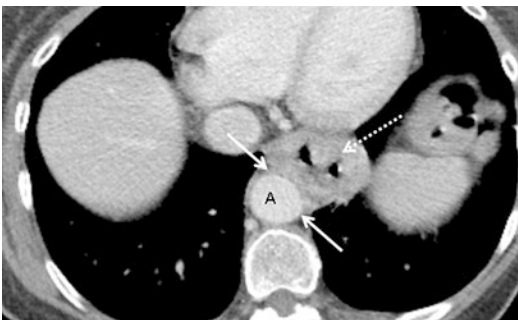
Axial CT image of a bulky, circumferential lower esophageal tumor (*dashed arrow*). The arc of contact with the thoracic aorta (A) is almost 180° (*solid arrows*), indicating T4 disease
